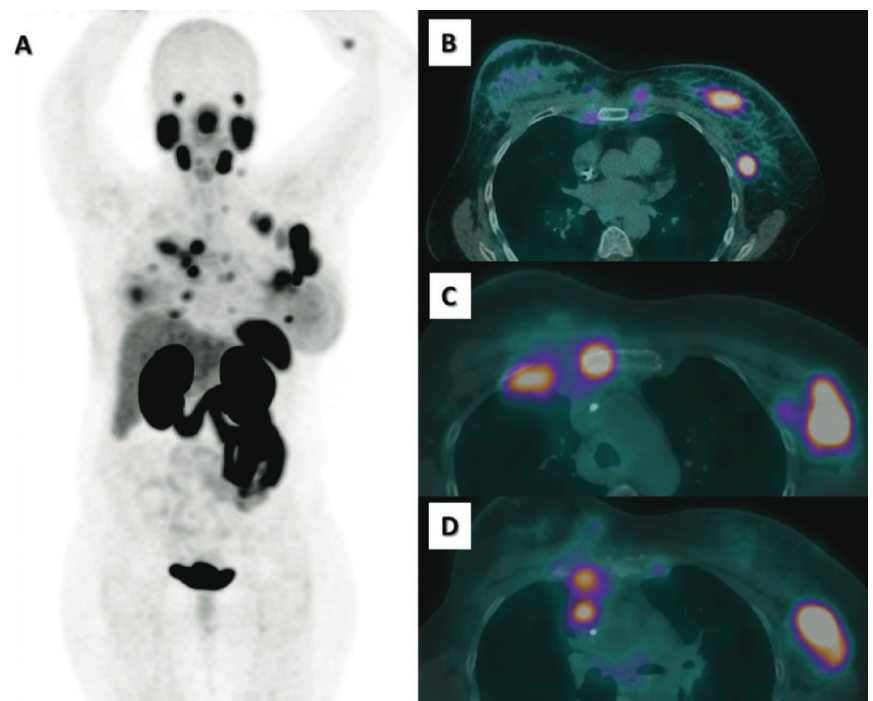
Maximum intensity projection (MIP) full-body images showing lesions with 68Ga-PSMA uptake at higher intensity compared to liver uptake (Fig. 2A). Tracer uptake can be observed in the breast and in axillary lymph nodes (Fig. 2B), in the sternum (Fig. 2C) and in anterior mediastinal lymph nodes (Fig. 2D).
